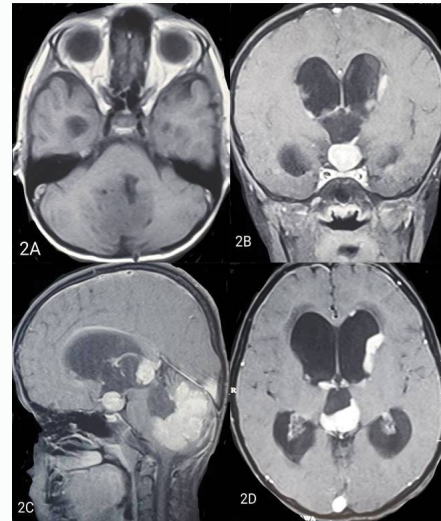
MR imaging of the brain showed tumor recurrence at the vermis (2A) with nodular metastasis at suprasellar, pineal region and ependymal lining of lateral ventricles (2b, 2C, 2D). Mismatching pattern of enhancement was seen between the recurrent tumor and nodular tumor deposits. The metastatic tumor deposits demonstrated intense enhancement on contrast. However the recurrent vermian tumor demonstrated mild enhancement on contrast similar to the primary tumor (2B, 2C, 2D).
